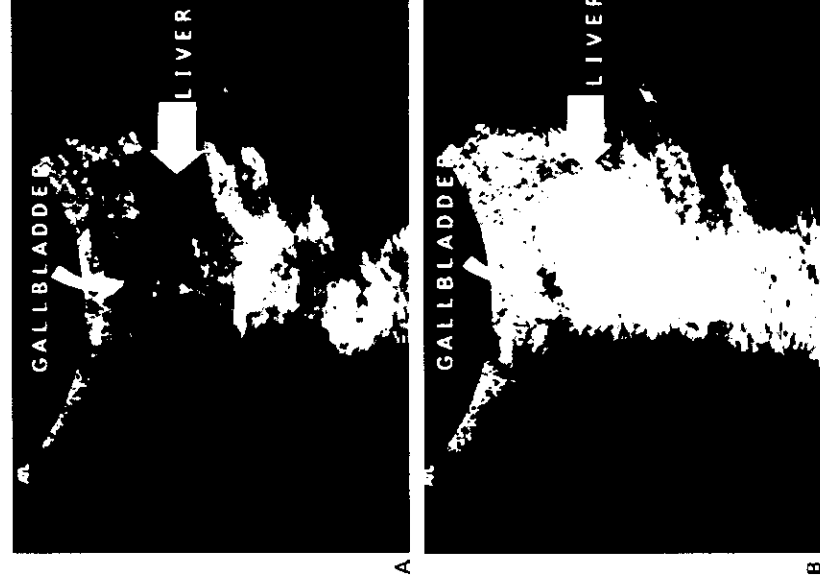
Sonograms of a rabbit liver before and after Levovist injection and pulse-inversion harmonic imaging. (A) Preinjection fundamental gray-scale sonogram shows the left lobe of the liver (arrow) and a normal anechoic gallbladder (curved arrow). (B) Sonogram obtained 5 seconds after contrast injection shows marked diffuse enhancement of the liver (arrow). The gallbladder is also indicated (curved arrow).
